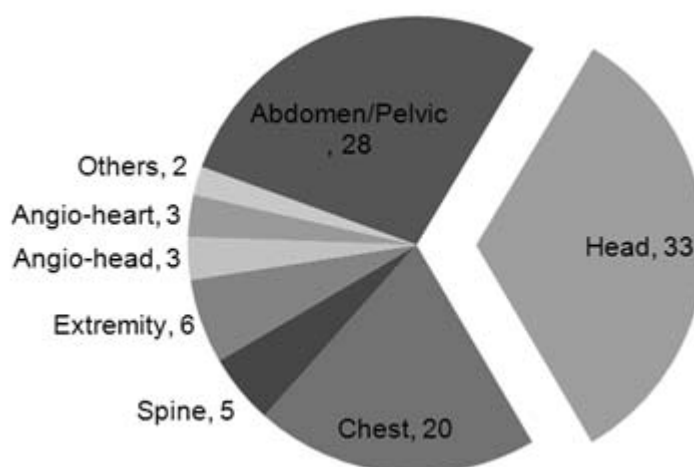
Frequency of the CT examinations performed in five hospitals evaluated
